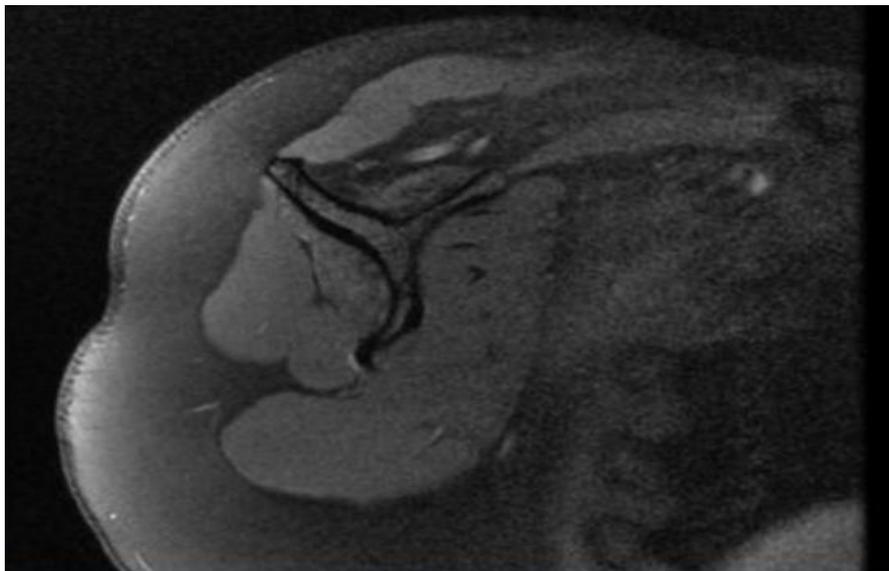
MRI of right shoulder (Sagittal) showing supraspinatus and infraspinatus atrophy.
